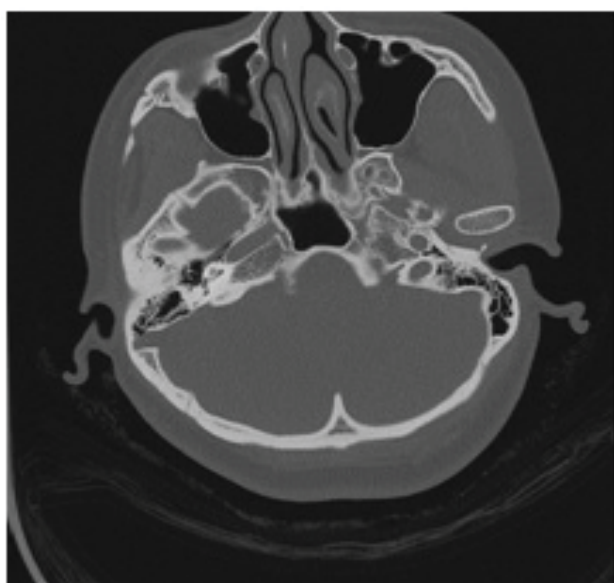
Temporal bone CT: Sigmoid sinus bone wall defect of the right ear, no obvious abnormality in left ear.
